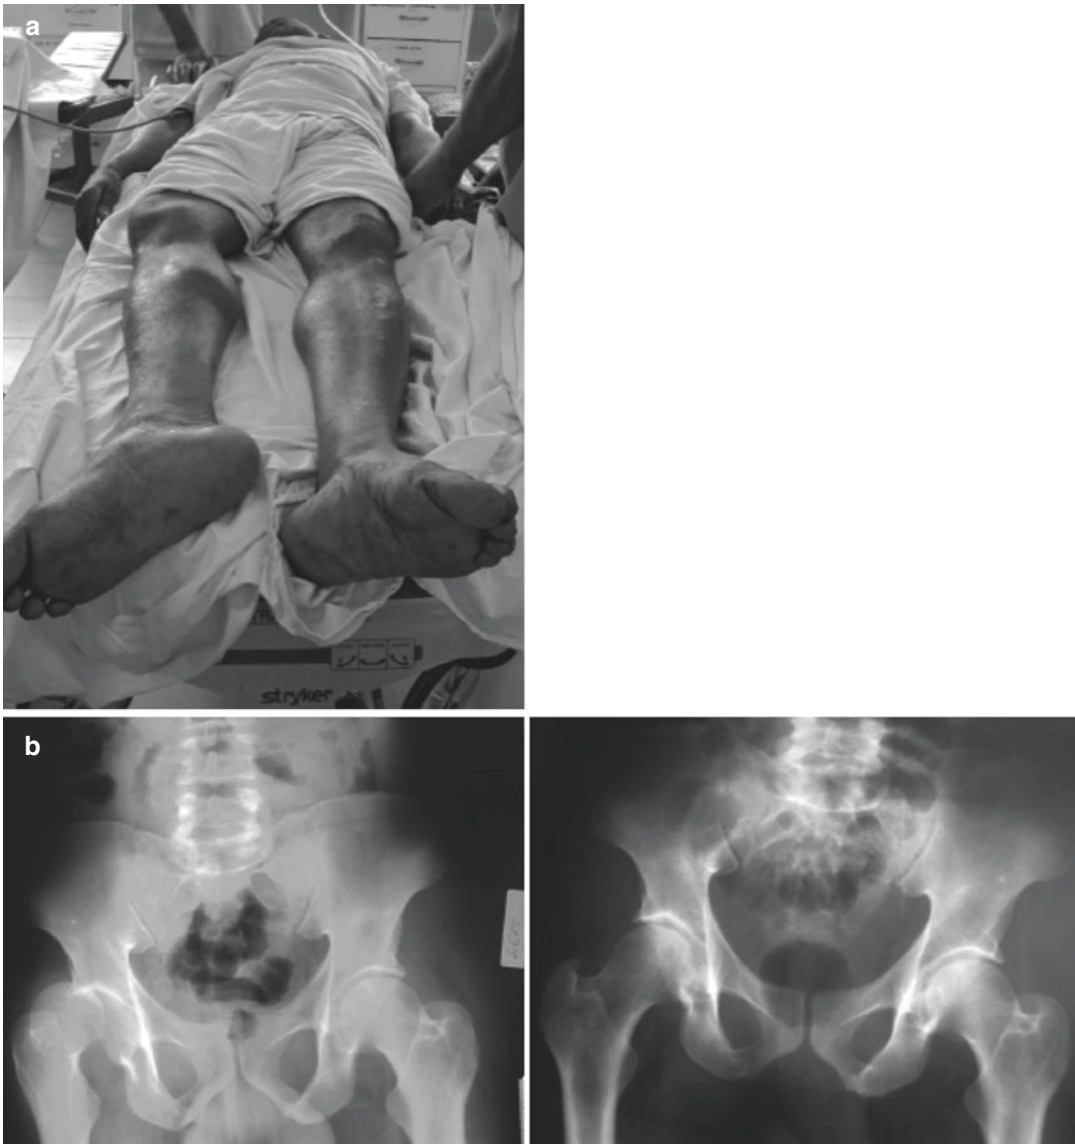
(a) The shortened, externally rotated right leg in an anterior dislocation of the hip caused when the farmer slipped and hyperextended his right leg 5 days before. (b) Pre- and postreduction x-rays of the pelvis
